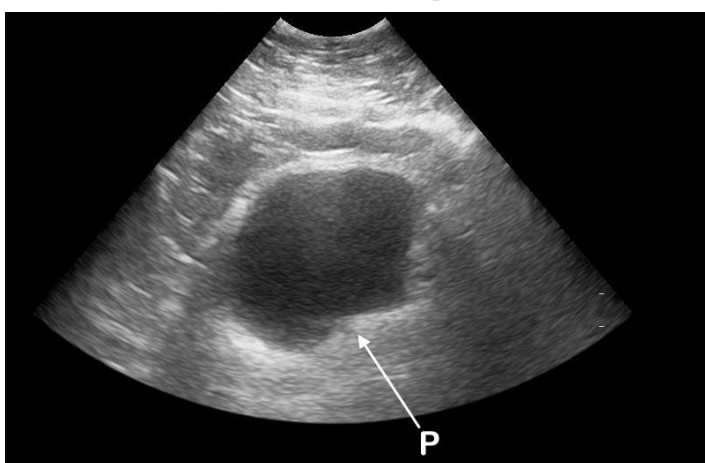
Emergency department ultrasound (EDUS). Inward protrusion (P) of the left posterior bladder wall.
